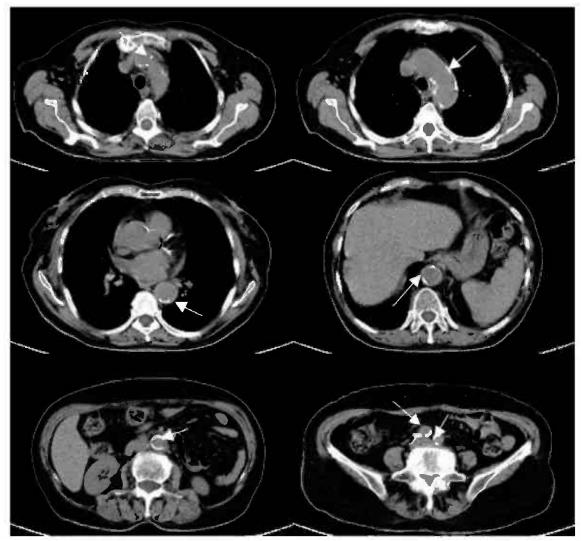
Unenhanced axial CT images of the thorax and abdomen show multifocal extensive calcifications (arrows) in the wall of the aorta until its bifurcation.
